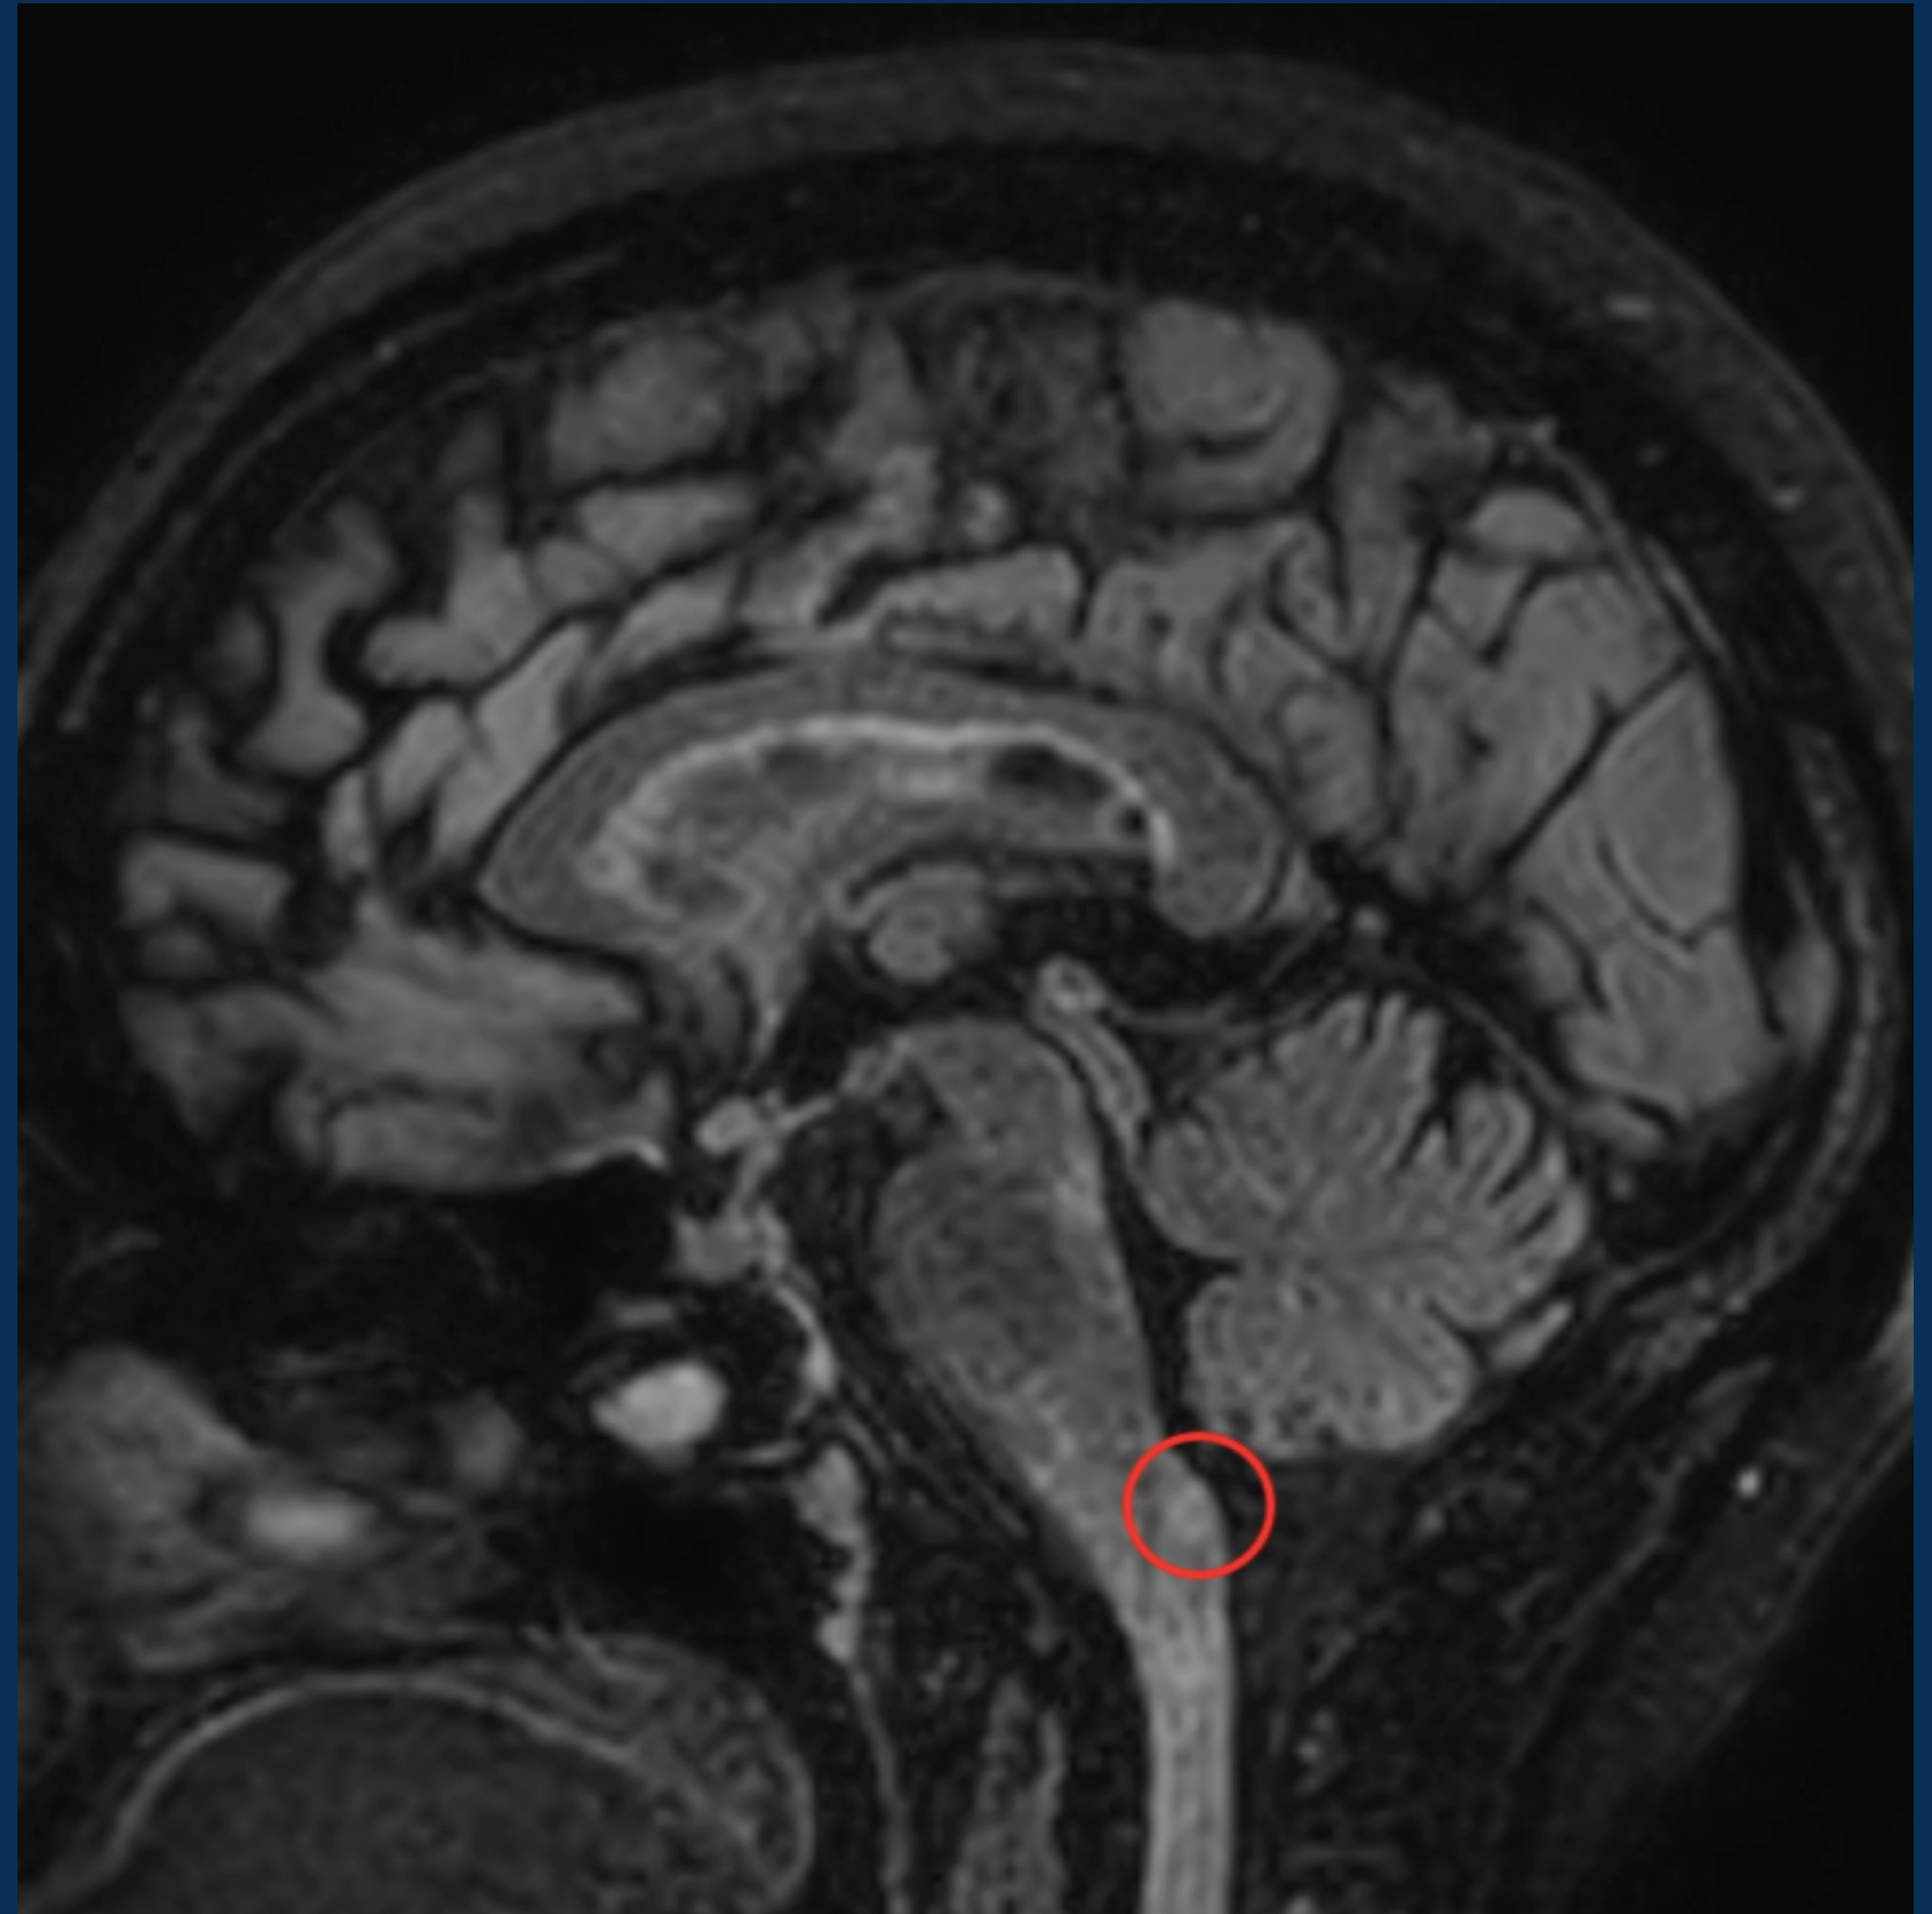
Sagittal T2 FLAIR of head with dorsal medulla hyperintensity (circle).
